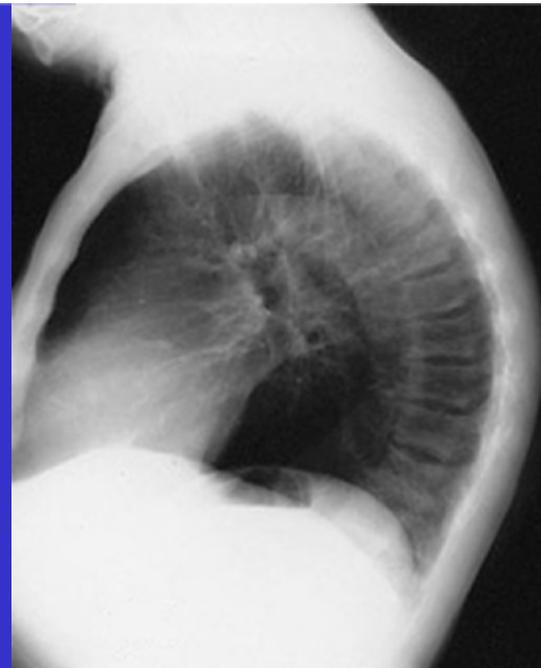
A rugger jersey spine is evident in this radiograph of a patient with primary hyperparathyroidism. There is marked osteopenia of the spine, with band-like sclerosis of the superior and inferior margins of the vertebral bodies, which suggests osteitis fibrosa cystica.
